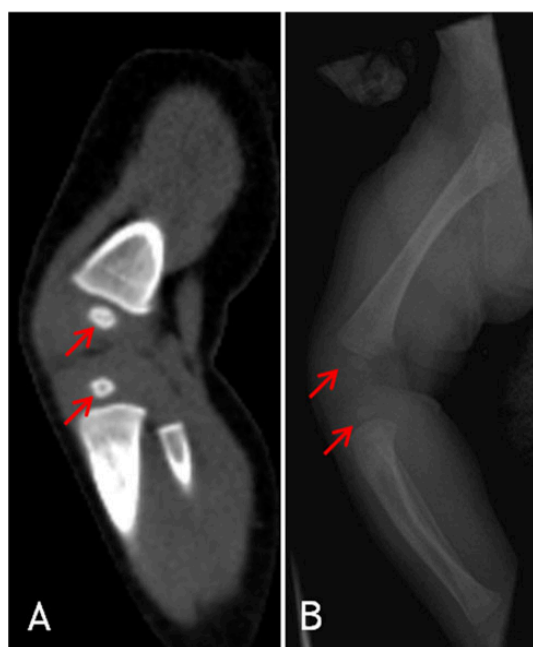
a MDCT reconstruction of the lower limb. Ossification sites can be seen clearly. b X-ray image. Ossification centres are visible, but not as clear as on MDCT image
